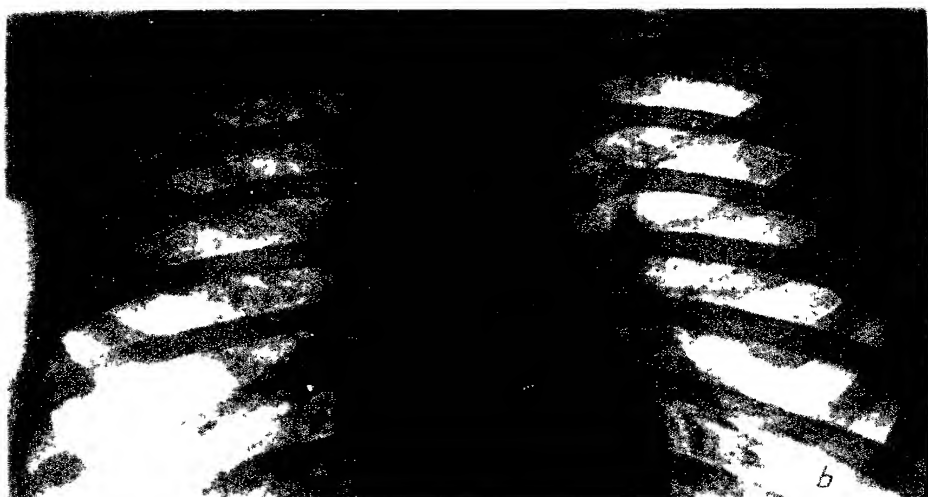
X-rays of the same case three years later Bilateral pulmonary tuberculosis with hematogenous dissemination
